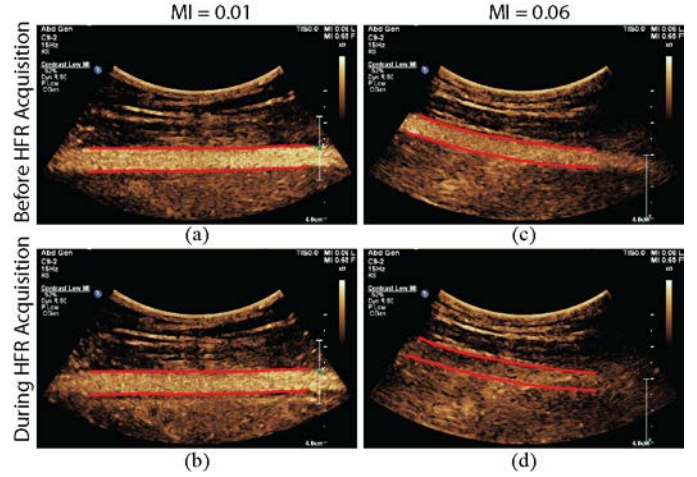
Contrast mode images recorded downstream from the abdominal aorta, in the left superficial femoral artery with a clinical ultrasound system. Images are recorded a few seconds before (a, c) and during (b, d) the high frame rate (HFR) acquisitions in the abdominal aorta, for MIs of 0.01 (a, b) and 0.06 (c, d). For 0.06 MI, note the dramatic reduction in contrast intensity before (c) and during (d) the HFR acquisition. This is not the case of 0.01 MI, where contrast intensities before (a) and during (b) HFR acquisition are very similar.
